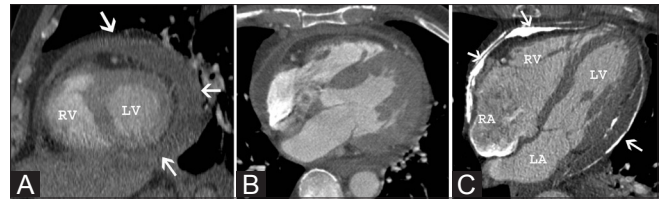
(A–C): Pericardial abnormalities. Sagittal reformatted CT image (A) shows a moderate-sized circumferential pericardial effusion (arrows). Axial CT image (B) in a patient with acute pericarditis shows thickening and enhancement of the visceral (straight arrow) and parietal pericardium (curved arrow); there is also surrounding small amount of pericardial fluid (arrowhead). Axial CT image (C) shows extensive calcification of the pericardial layers (arrows). In addition, there is conical deformity of the right ventricle and tubular deformity of the left ventricle, features that are suggestive of pericardial constriction
